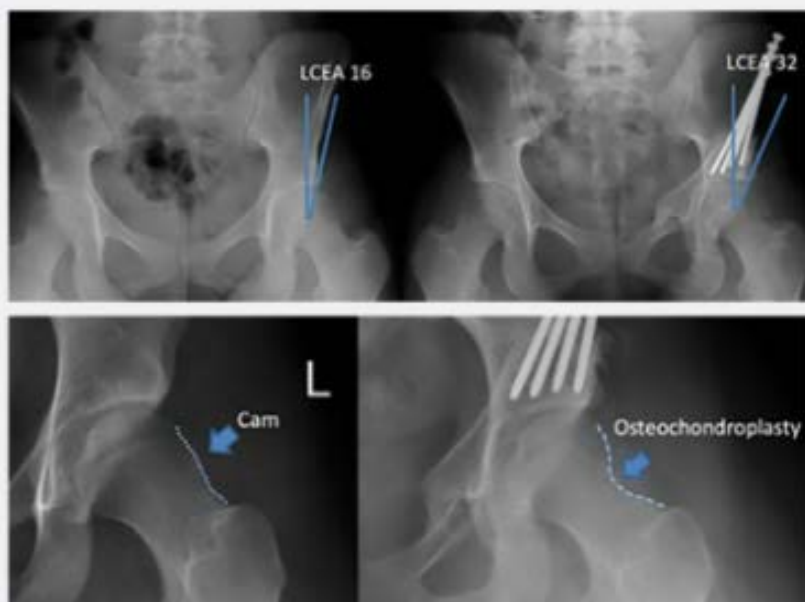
18-year-old female hockey goalie with LCEA 16 degrees treated with periacetabular osteotomy and hip arthroscopy. Femoral version measured 10 degrees on CT.
